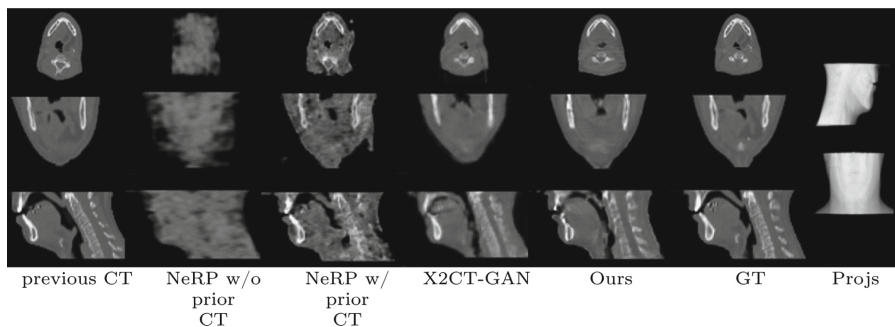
Visual comparison of 3D reconstruction from biplanar projections by our model and baselines. Without a previous CT volume, NeRP fails by lack of constraints. When initialized with an earlier CT (left), NeRP tends to create artefacts to match the projections rather than really change the anatomy. Our method produces better matching structures than X2CT-GAN, almost matching the CT volume deformed on the CBCT volume (GT, right).
